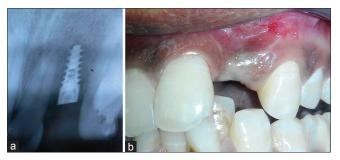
Postoperative radiograph (a); 1-week postoperative soft-tissue contour (b)
